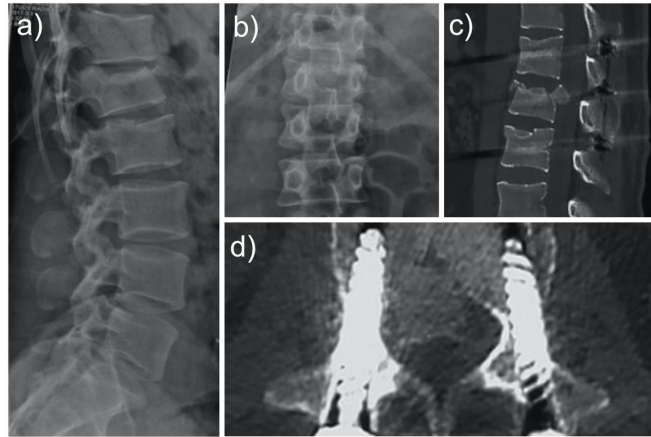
Lateral (a) and anteroposterior (b) x-rays of the lumbar spine vertebrae showing L1 (burst) and L2 (compression) vertebral fracture are shown. The patient underwent percutaneous short pedicle screw fixation which did not reduce the posterior wall fragments. Postoperative CT scan of the lumbar spine showed large bone fragments to remain in the spinal canal typical of a burst fracture.
